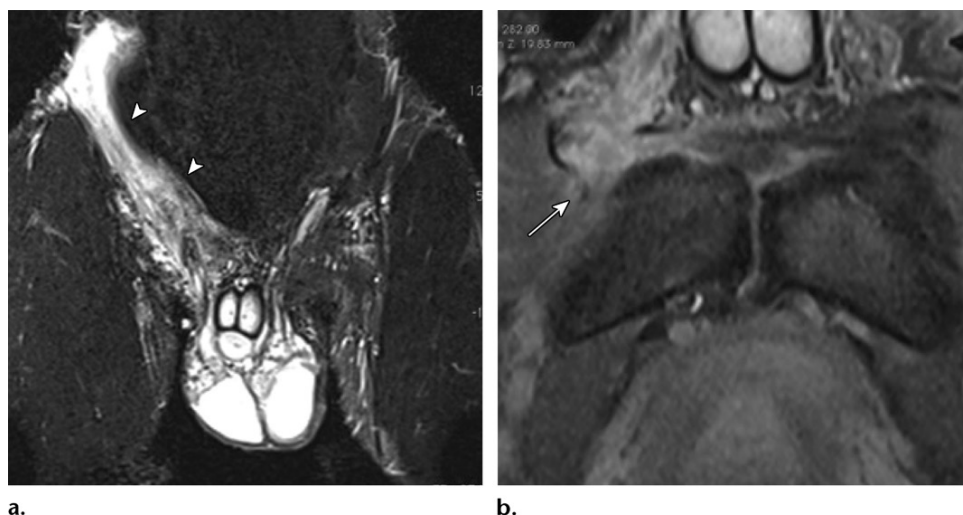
Groin pain caused by a tear of the adductor longus tendon in a 30-year-old man immediately after weight lifting. Coronal (a) and axial (b) short inversion time inversion-recovery MR images show extensive edema in the right inguinal and parasymphyseal region (arrowheads on a) and a torn adductor aponeurosis (arrow on b).
